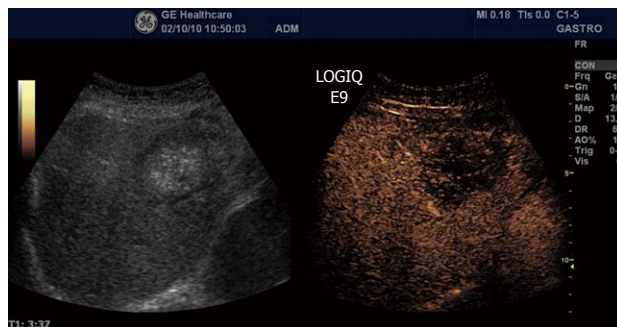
Contrast-enhanced ultrasound B-mode image of a colon cancer metastasis (same as in Figure 5) in the sinusoidal (late) phase, showing marked hypoenhancement in the right panel.
